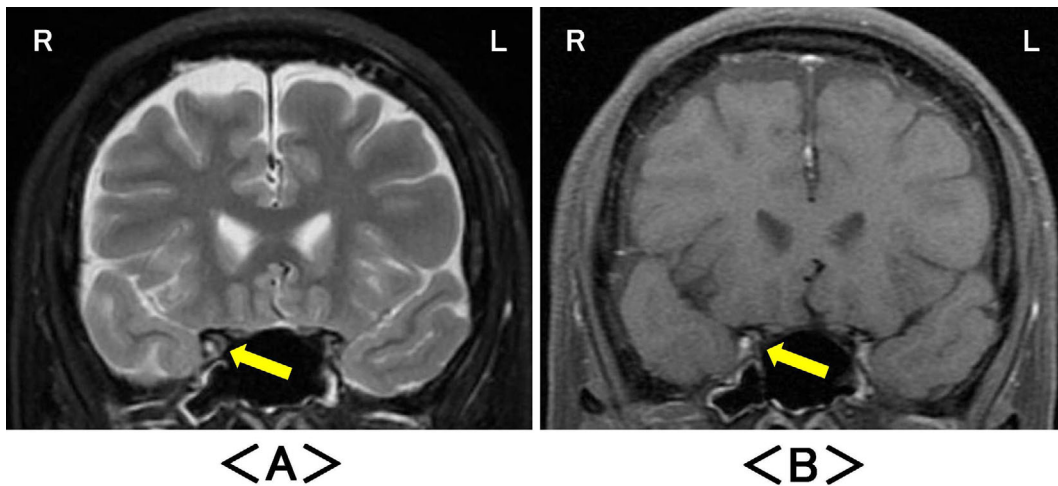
Coronal intra-orbital magnetic resonance imaging on day 5 after the onset of influenza symptoms revealed the significant enlargement and the enhancement of the right oculomotor nerve on (A) fat-suppressed T2-weighted images (arrow) and (B) fat-suppressed T1-weighted images with gadolinium enhancement (arrow). R: right, L: left
